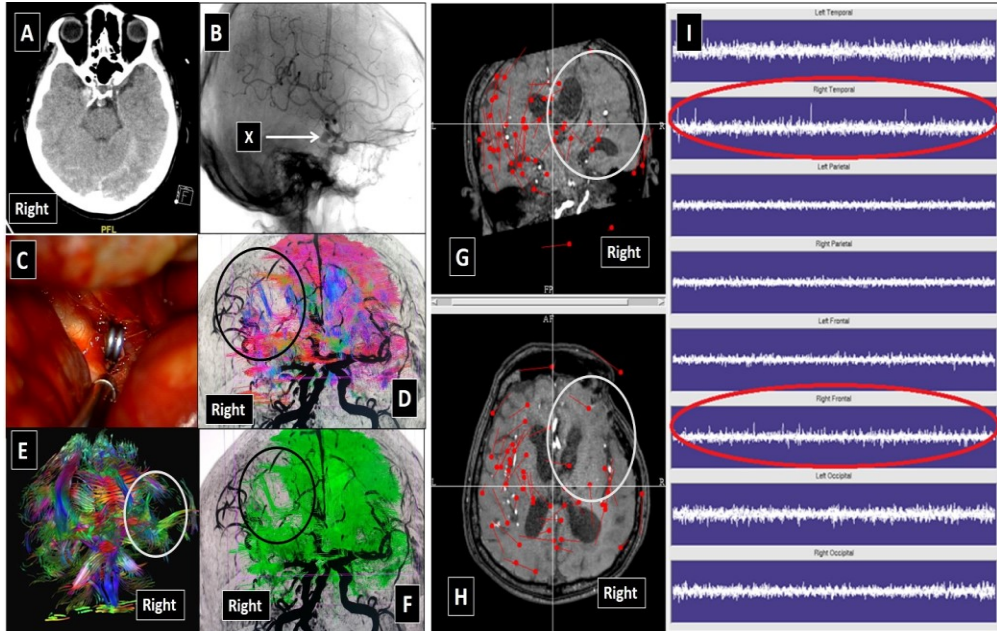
An ACOM aneurysmal SAH and low brain energy. A: Head CT images showed diffuse SAH. B: ACOM saccular aneurysm demonstrated on CT angiography (white arrow). C: post-operative DTI depicted lack of the orbitofrontal white matter fibers (white circle). D: post-operative MEG spontaneous brainwave analysis overlaid onto the brain MRI axial image. The red dots indicated tabulation of the active pathway during the scan. The collection of events (red dots) demonstrated lack of brain activation in the bilateral frontal lobes (white circle). E: MEG results also indicated lower amplitude or energy for both frontal lobes (red circle).
